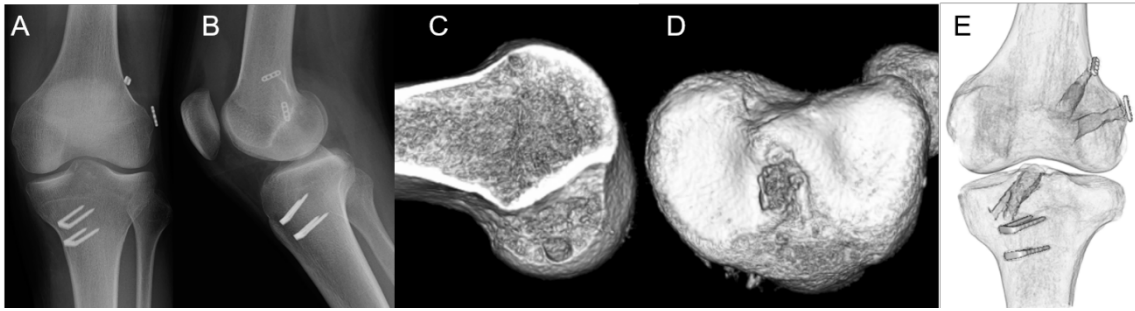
Postoperative radiograph and imaging of computed tomography (CT) of the left knee. (a) Anteroposterior radiograph of the left knee joint. (b) Lateral view of the left knee joint. (c) Postoperative 3-dimensional CT image of the femur and (d) the tibia showed that the 2 tunnels were created at the expected positions. (e) The transparent 3-dimensional CT image of the left knee represents 2 tunnels intuitively.
